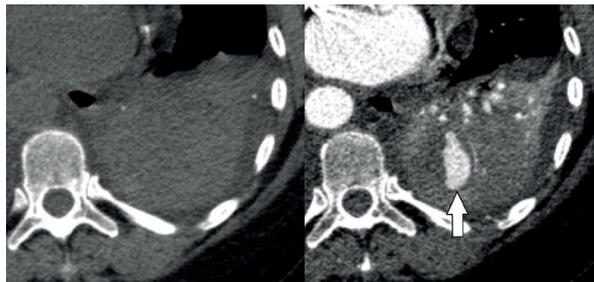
Unenhanced CT scan (left image) shows left lower lobe consolidation and contrast-enhanced CT scan (right image) shows area of enhancement corresponding to pseudoaneurysm lumen (arrow).
